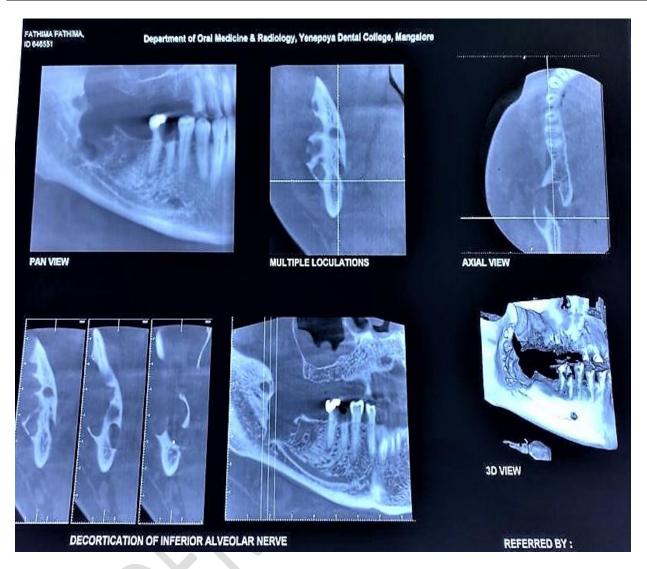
Orthopantomogram revealed a multilocular radiolucency with ill-defined borders extending anteroposteriorly from 46 to the ascending part of the ramus, and superioinferiorly from the upper border of the mandible till the mandibular canal. Computed Tomography scan revealed an evidence of buccal and lingual cortical perforation and bone marrow space involvement approximating mandibular canal.
